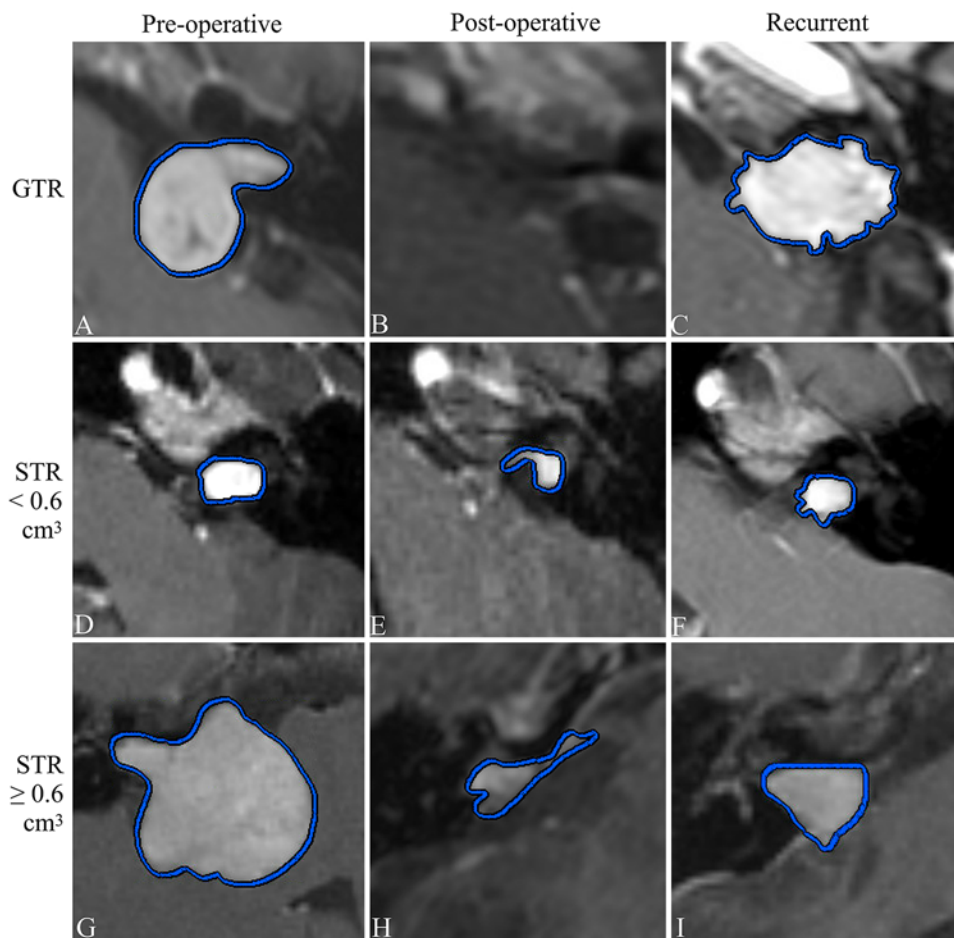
T1-weighted postcontrast MR images showing preoperative (A), postoperative (B), and recurrent tumor (C) in a patient receiving GTR. Preoperative (D), postoperative (E), and recurrent tumor (F) in a patient receiving STR with residual $< 0.60 \text{ cm}^3$. Preoperative (G), postoperative (H), and recurrent tumor (I) in a patient receiving STR with residual $> 0.60 \text{ cm}^3$. Figure is available in color online only.
